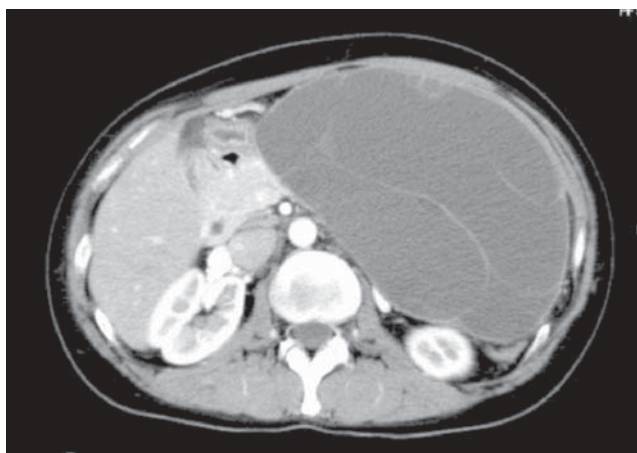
Abdominal computed tomography scan shows a multilocular cystic lesion of the pancreas, 18 cm in diameter, without solid components
